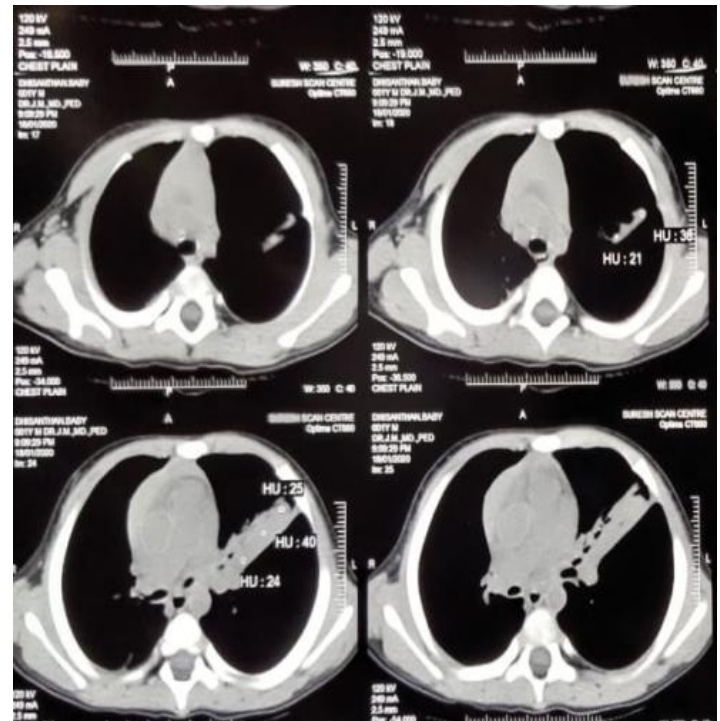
CT chest image shows hyper inflated left lung field and patchy infiltration due to FB
